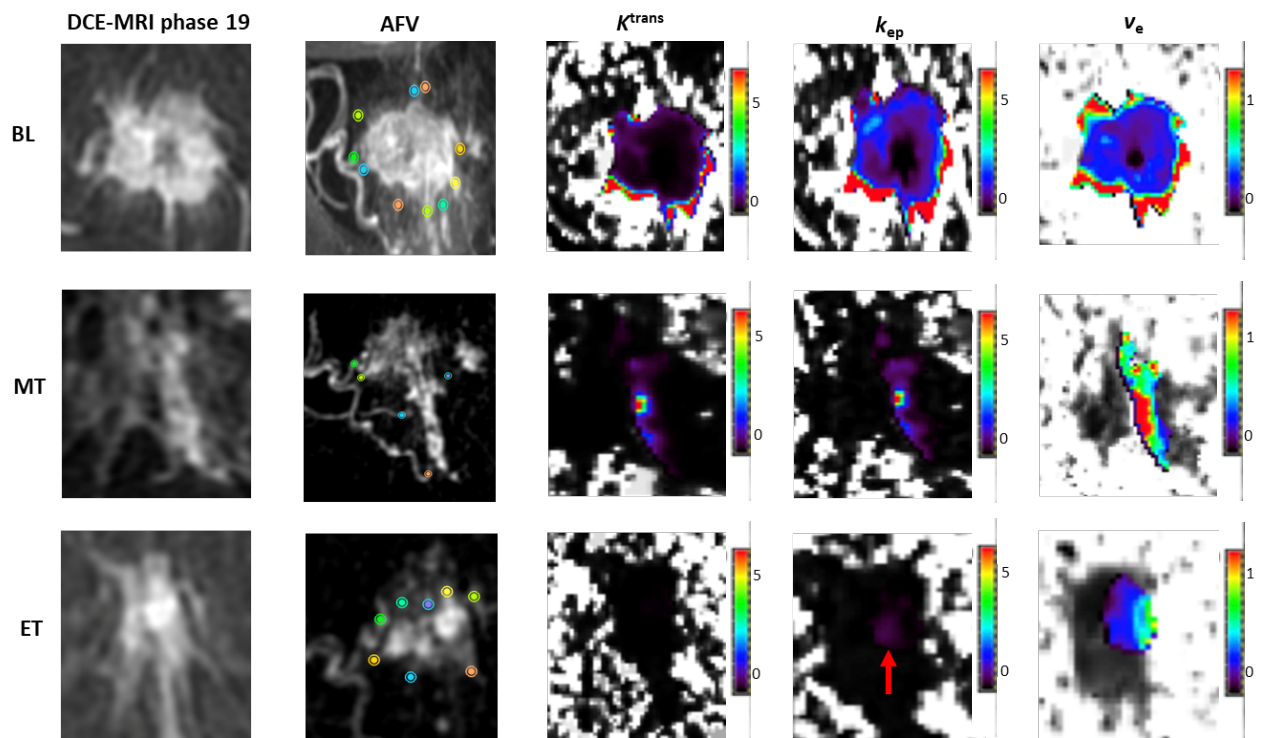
60-year-old female patient presenting with a triple-negative, grade 2 carcinoma of no specific type (NST). The patient showed pathological complete response (pCR) after surgery and radiological partial response after neoadjuvant chemotherapy (NAC). The patient received taxane and anthracycline-based treatment for 6 cycles in total. The cancer is shown at three time points during NAC: baseline (BL), mid-treatment (MT) and at the end of treatment (ET). The red arrow on the K_{ep} map at the end of treatment points out a small lesion observed in purple. *Left to right*: DCE-MR image at peak enhancement (phase 19); maximum intensity projection (MIP) image depicting the tumour adjacent feeding vessels (AFV); K^{trans} , k_{ep} and v_e maps of the lesion.
